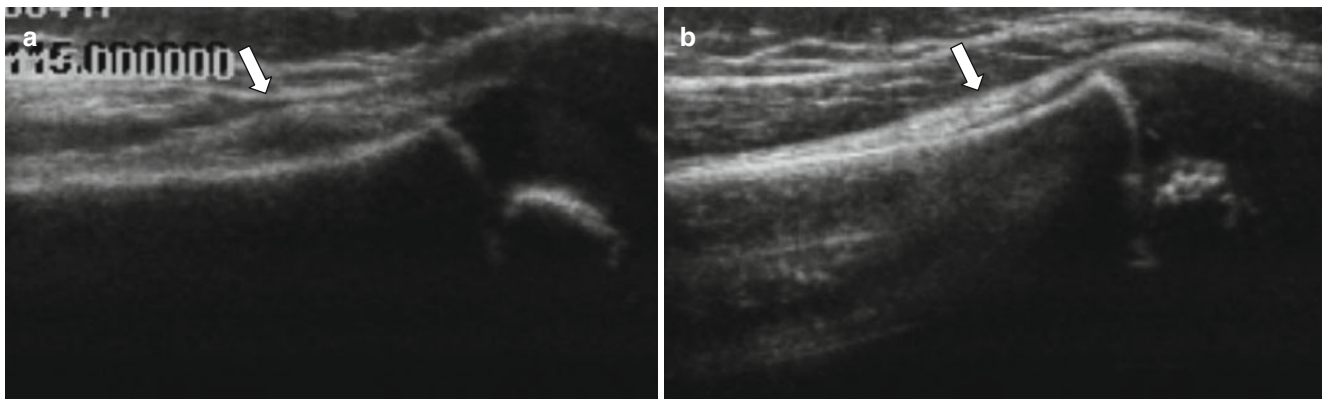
A 5-year-old girl with subperiosteal abscess. (a) Ultrasound exam of the right femur demonstrates periosteal lifting with subperiosteal fluid (arrow). (b) Exam of the contralateral side demonstrates normal appearance of the periosteum (arrow)
